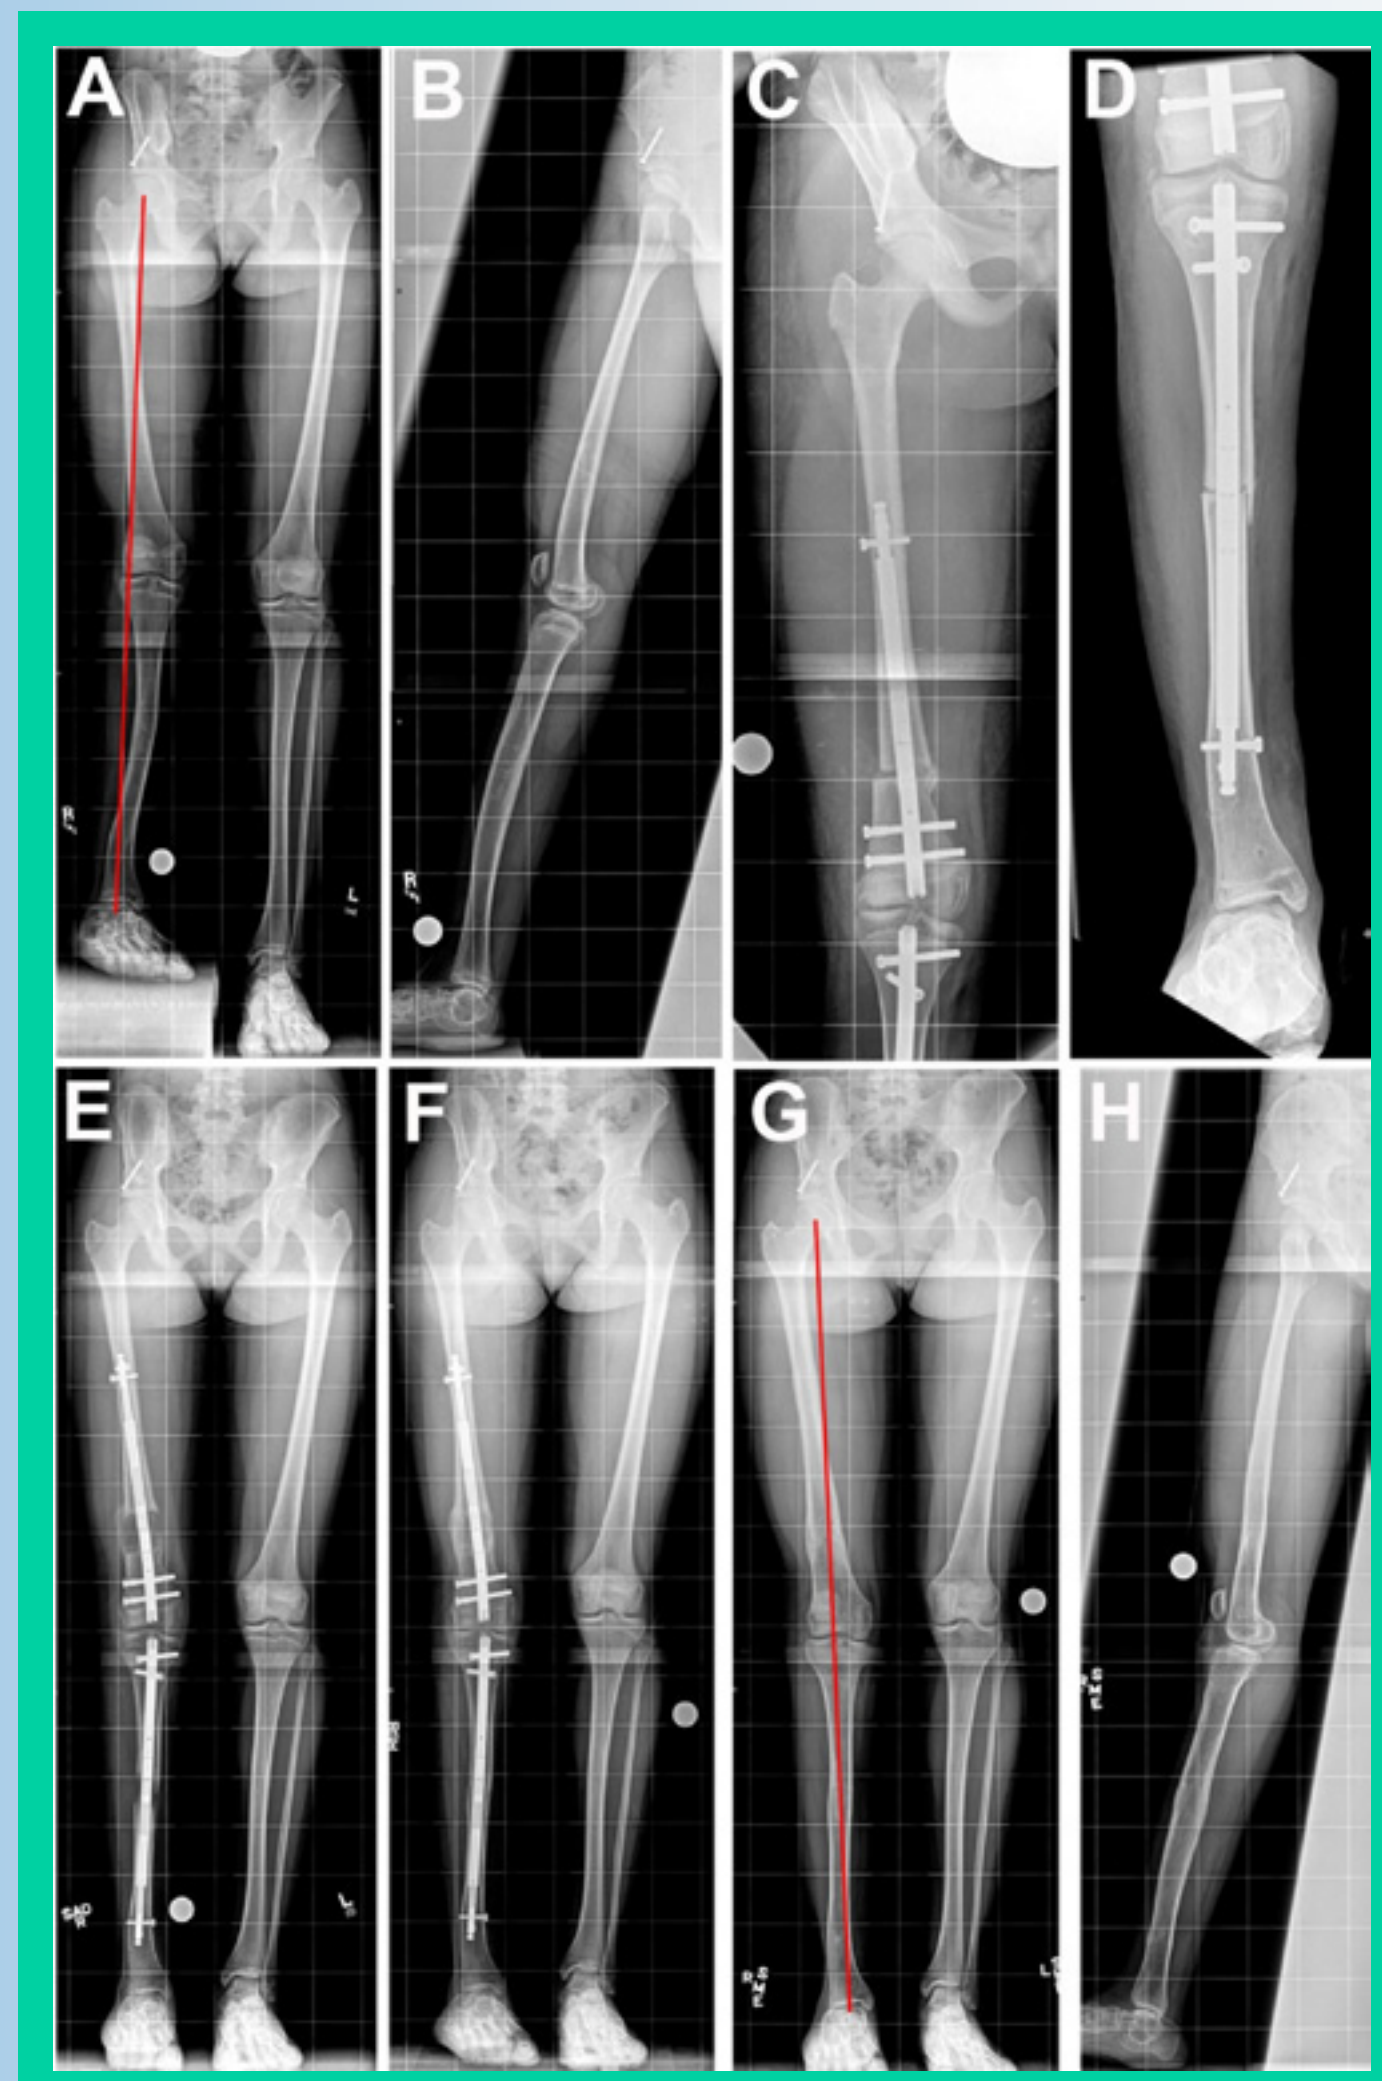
Fourteen-year-old girl with congenital femoral deficiency and fibular hemimelia of the right limb. A and B, AP (A) and lateral (B) view preoperative radiographs show lateral mechanical axis deviation, 3.5-cm femoral discrepancy, and 7° femoral valgus. The patient also has 6-cm tibial discrepancy, 9° tibial valgus, 3° tibial procurvatum, and 10° internal tibial torsion. C and D, Radiographs obtained immediately after acute deformity correction and insertion of lengthening nails into the femur (C) and tibia (D). E, Radiograph obtained after complete distraction. F, Consolidation of the regenerate achieved. G and H, AP (G) and lateral (H) view radiographs obtained after nails removed. Note that the limb alignment has been corrected.
